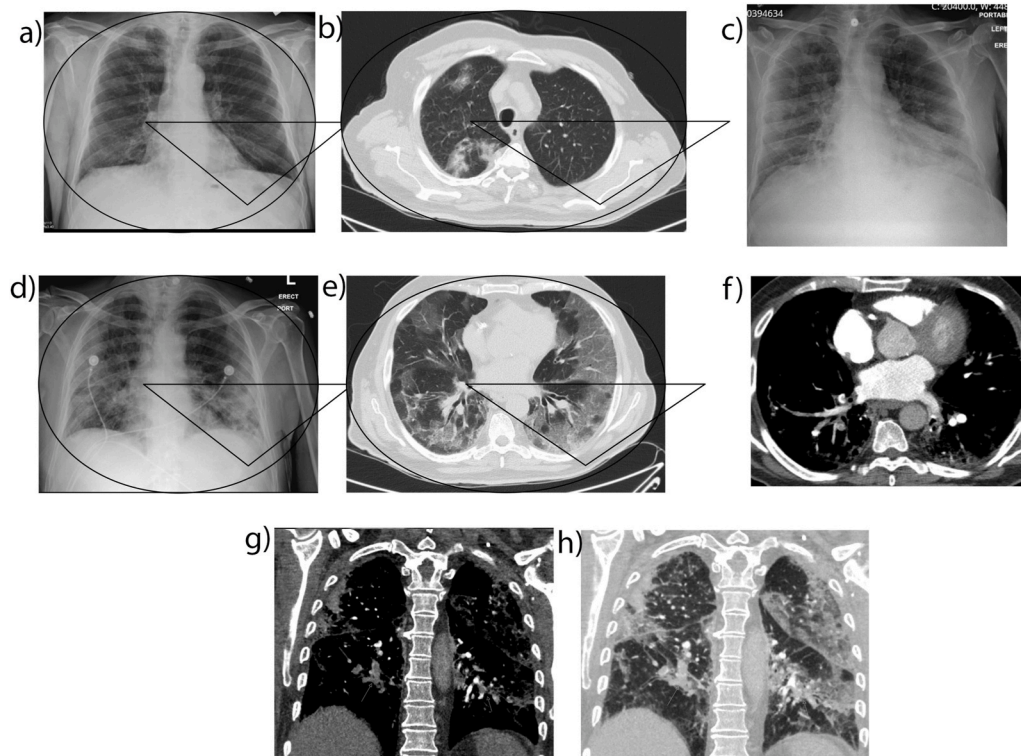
3A & 3B (left to right clockwise): Admission CXR with nodular right upper lobe opacity. Admission CT chest showing multifocal peripheral distribution of GGO. Fig. 3C: Discharge CXR showing improved right upper lobe opacity with linear atelectasis at the bases. Fig. 3D and E and (left to right): Readmission CXR with patchy bilateral opacities. Readmission CT chest demonstrates diffuse GGO with crazy paving. Fig. 3F, G & 3H: CT angiogram shows features of bilateral lower lobe thrombi. Readmission CT chest demonstrates diffuse GGO with crazy paving.
